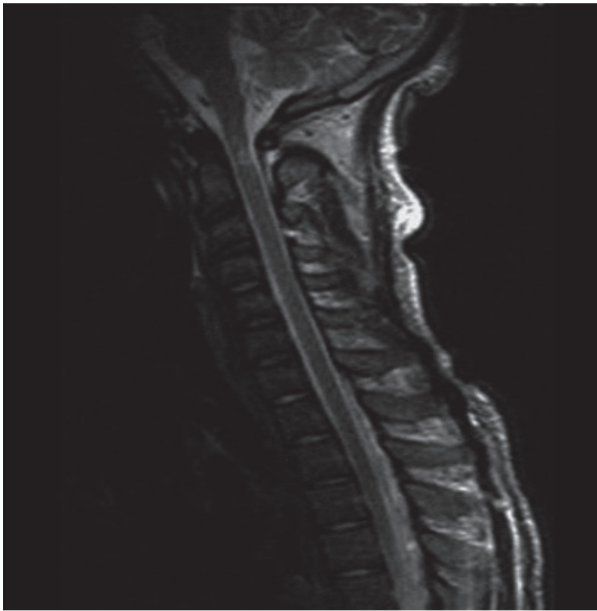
MRI T2 Spine Revealing Normal C1-C2 Articulation, No Evidence of Subluxation, a Posterior Hematoma at C2 Level and Hematoma in the Cord
